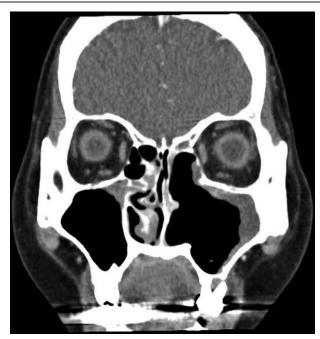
Coronal computed tomogram showed no evidence of tumor recurrence at 18-month follow-up.
